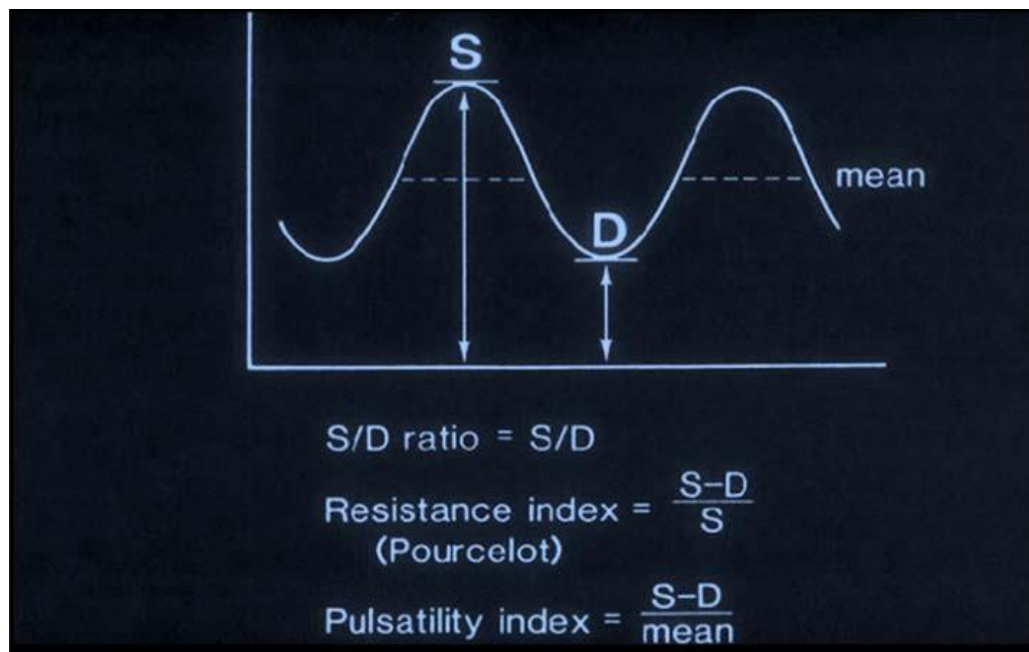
Doppler indices
